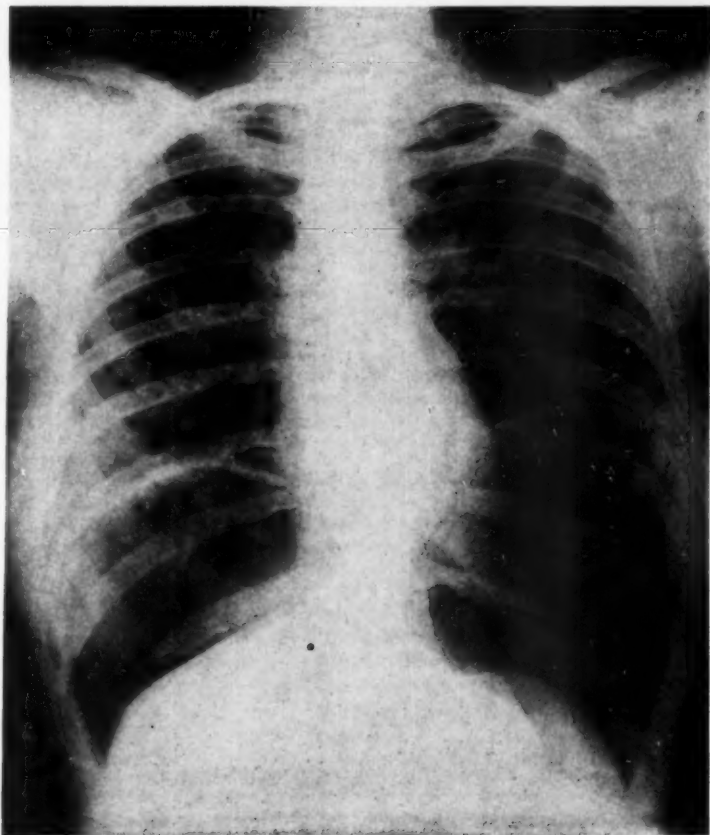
Chest roentgenogram taken October 22, 1951, showing disappearance of all cavities and control of disease in both lungs 10 months after beginning retreatment with combined streptomycin-PAS.
